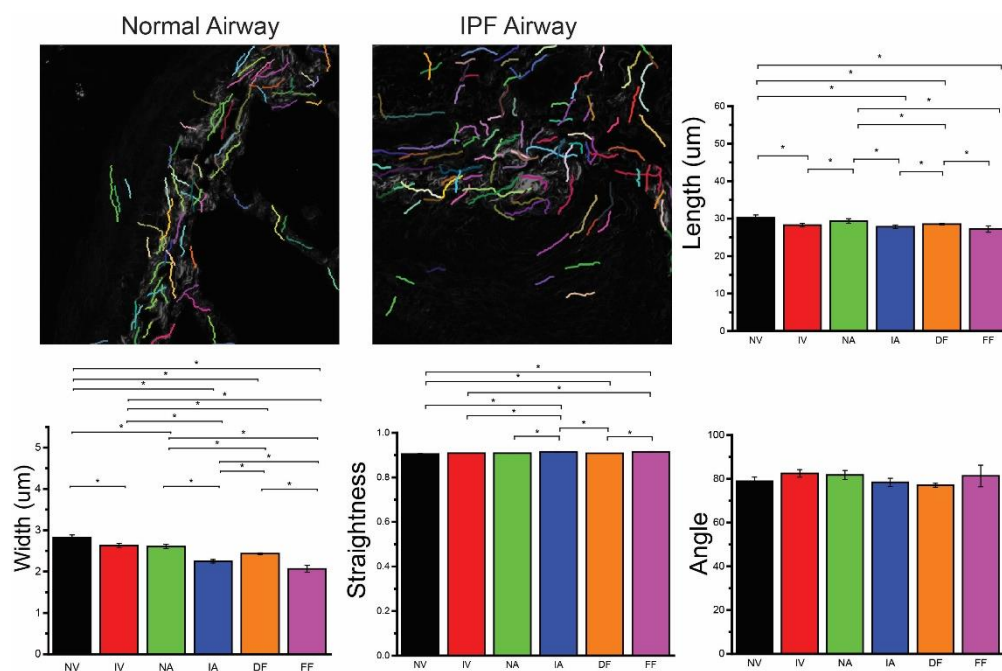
Average CT-FIRE data for the specific regions. Representative CT-FIRE images of collagen of normal and diseased airways. Local width data comparing normal (black) and IPF (red) vessels, normal (green) and IPF (blue) airways, dense fibrosis (orange), and fibroblastic foci (purple) were assessed. Standard error bars are shown. * Denotes p-values < 0.5. Field of view = 300 x 300 µm.
